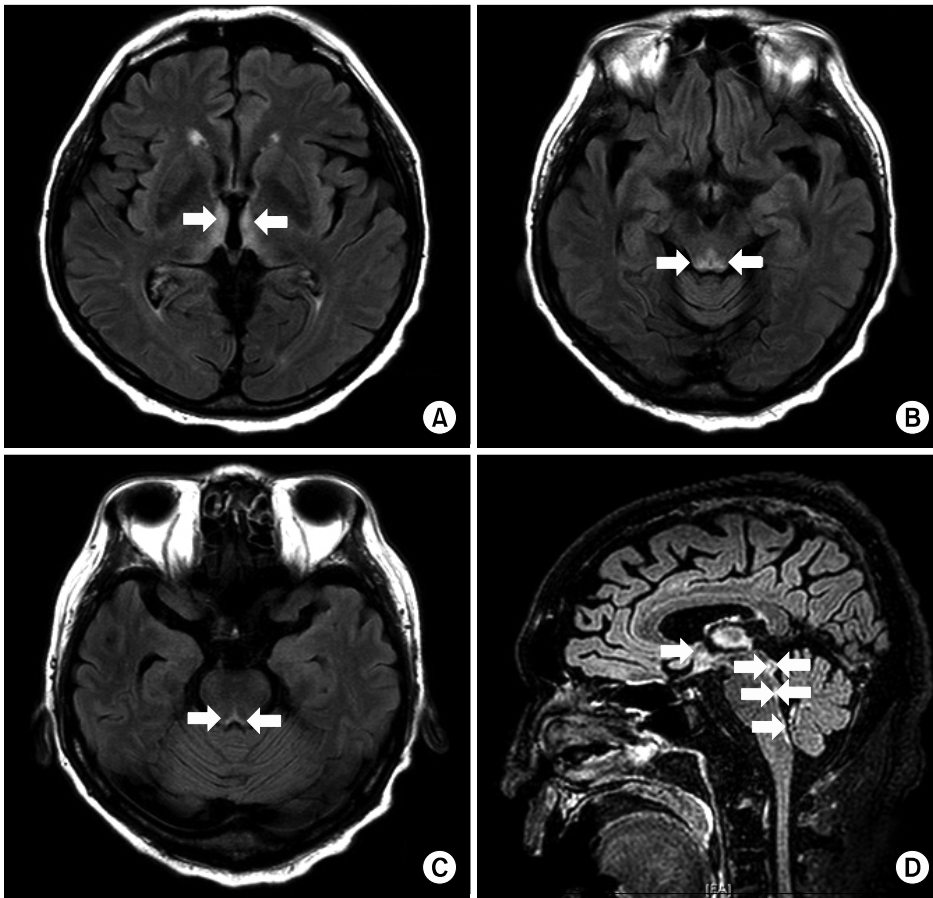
Fluid-attenuated inversion recovery-weighted axial (A-C) and sagittal (D) magnetic resonance imaging scans showed abnormal, symmetrical, hyperintense signal (arrows) in the bilateral medial thalami, dorsal midbrain, and medulla.
